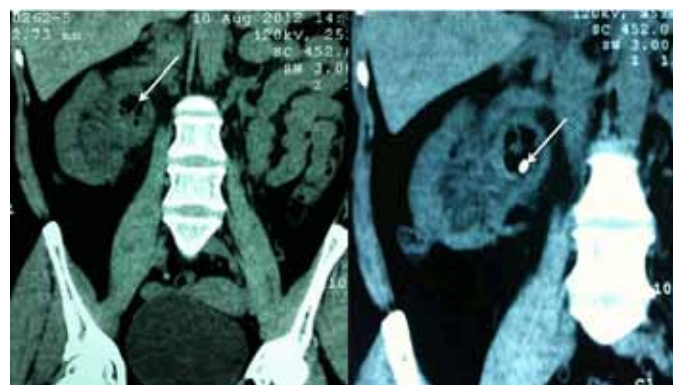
Computed tomography scan image showing increased right kidney, with heterogeneous lesion with gaseous component (left arrow) and calcified image (right arrow).
